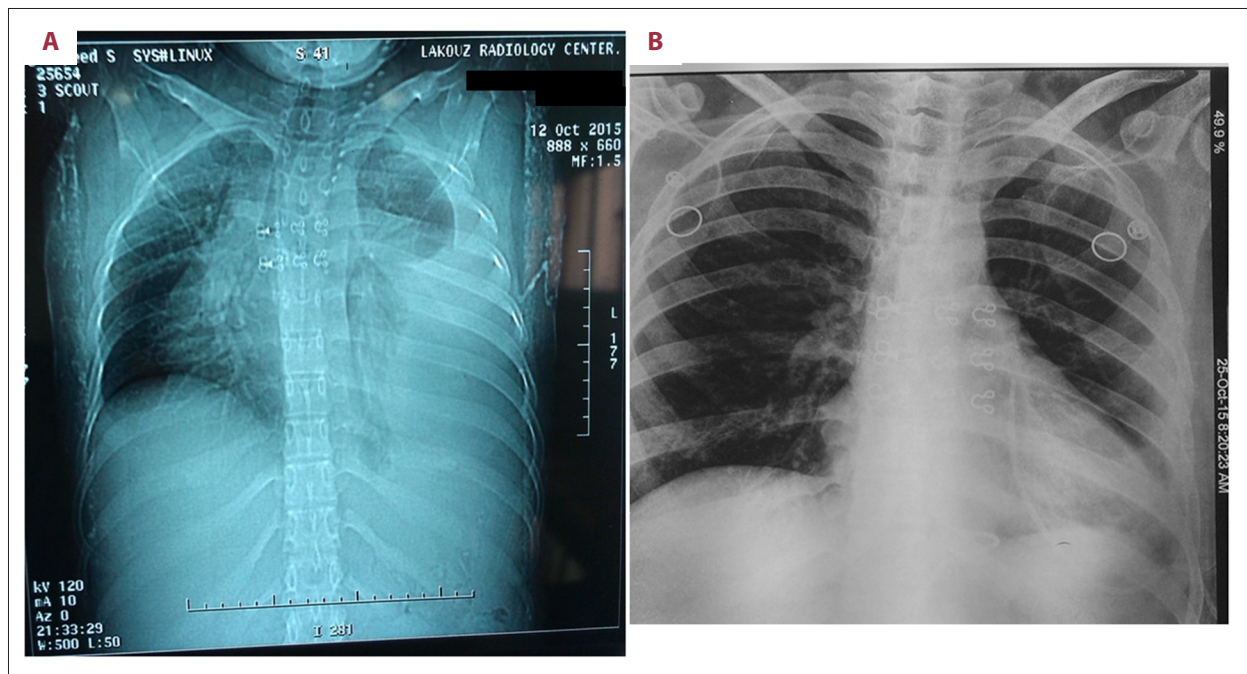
(A) Chest radiograph taken in the Emergency Department showed a large cardiac shadow without any significant lung pathology. (A) Before aspiration and (B) after pleural and pericardial aspiration with intercostal and pericardial drain still *in situ*.
